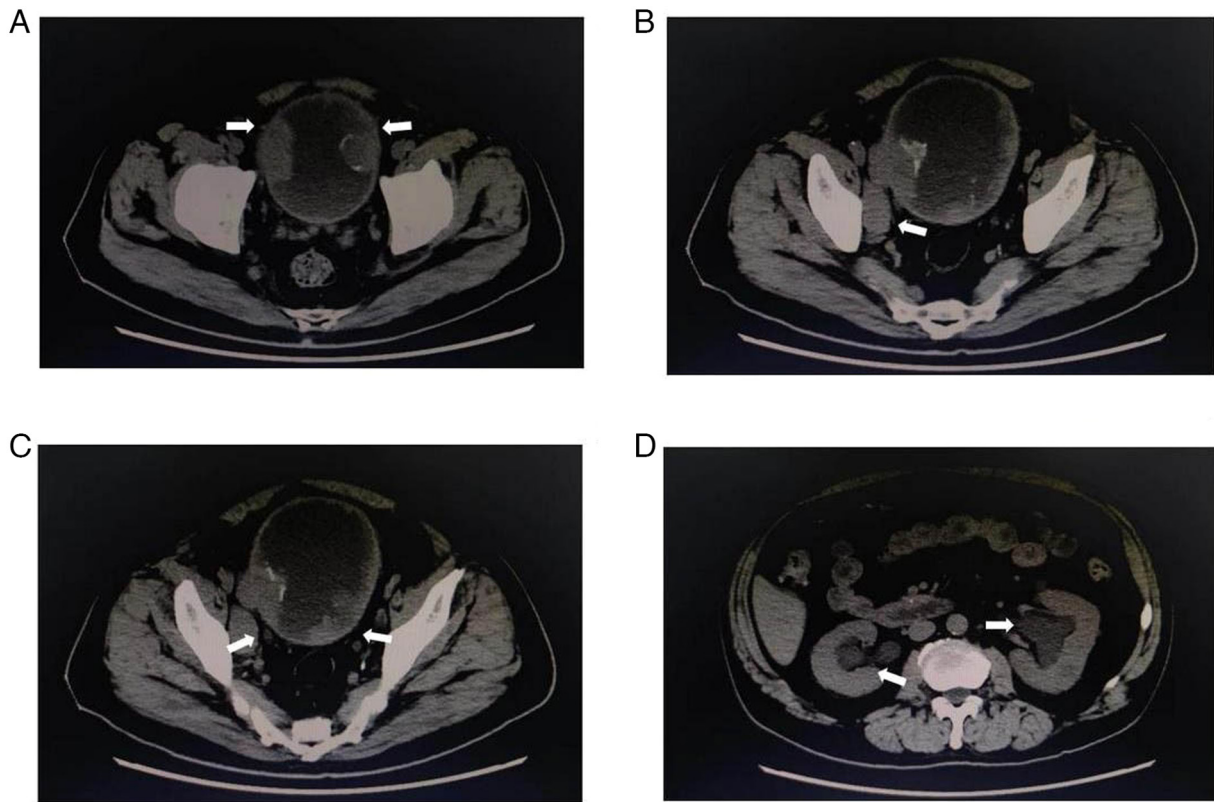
Urology computed tomography scan revealed (A) multiple tumors in the bladder (indicated by arrowheads), (B) multiple lymphadenopathies in the pelvis and along the right iliac artery (indicated by arrowheads), and (C) bilateral ureter bladder entrance invasion (indicated by arrowheads), (D) resulting in bilateral renal pelvis and ureter dilatation (indicated by arrowheads).
